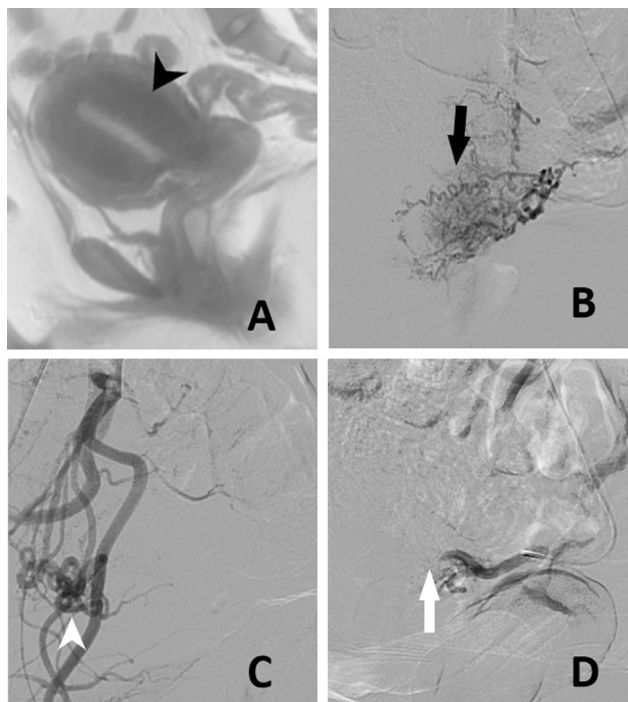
A 37-year-old female patient is a known case of adenomyosis. She underwent bilateral UAE with 300 to 50 micron-sized PVA particles. Image A-Sagittal MRI shows increased junctional zone thickness of more than 12 mm (arrowhead). Angiogram shows dilated tortuous bilateral uterine arteries with multiple feeders supplying the uterus (arrow in image B and arrowhead in image C). Post embolization angiogram shows occlusion of the uterine artery.
